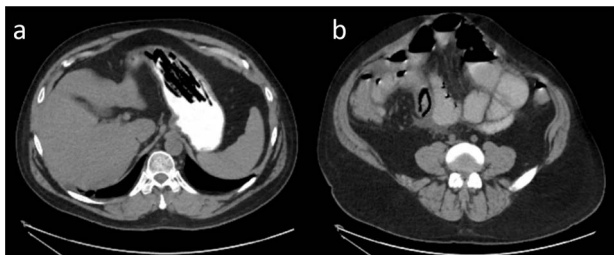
(a) Axial CT of the abdomen with oral contrast shows filling defects with stacked, linear objects in the stomach, consistent with possible foreign body ingestion. (b) Axial CT with oral contrast shows dilated loops of small bowel, with a triangular intraluminal filling defect. The previously noted “bowel-within-bowel” appearance is no longer seen. Possible foreign body defect that measured ~3.5 cm in length.
